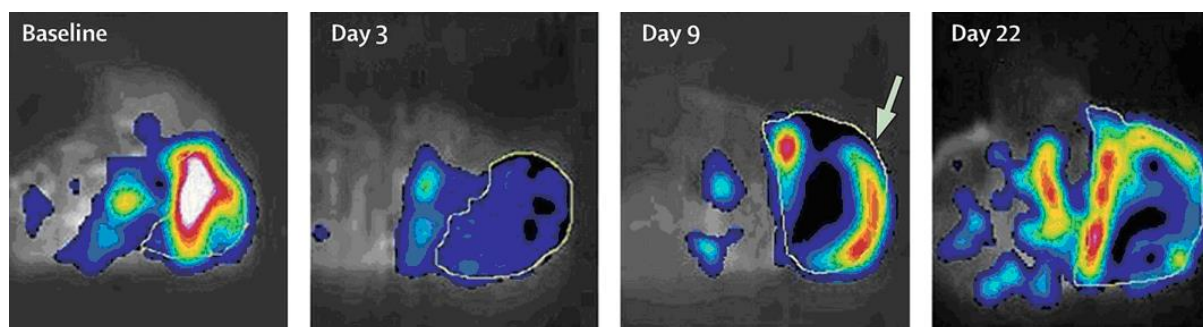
ASL MRI shows decreased signal on day 3 with return of peripheral signal from Day 9 to 22. Courtesy of Schor-Bardach et al. (71)
